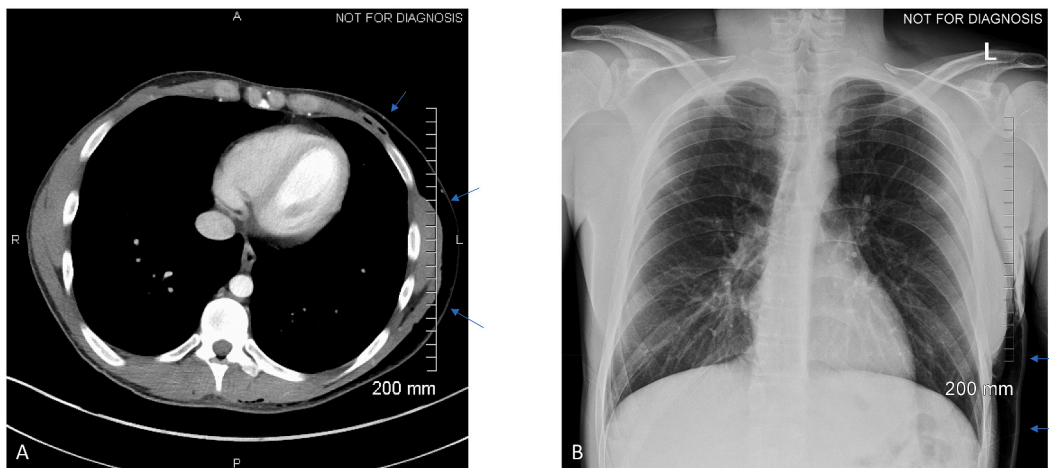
2A CT of the chest with contrast demonstrated extensive left-sided subcutaneous emphysema. 2B Chest x-ray revealed subcutaneous air in the left lateral lower thorax.
